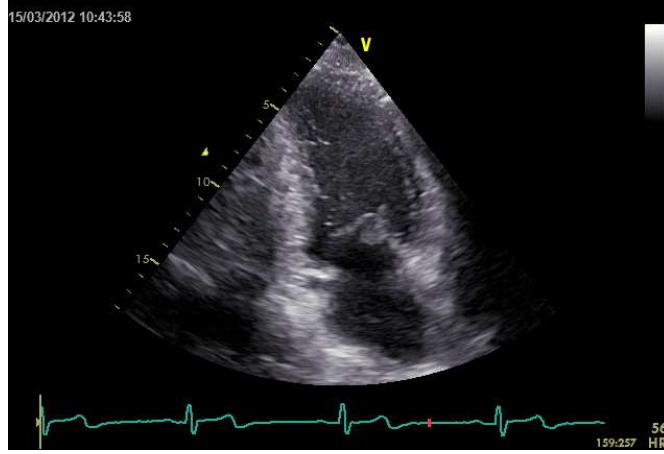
Ultrasound image of the heart from GE-Vivid E9.*
